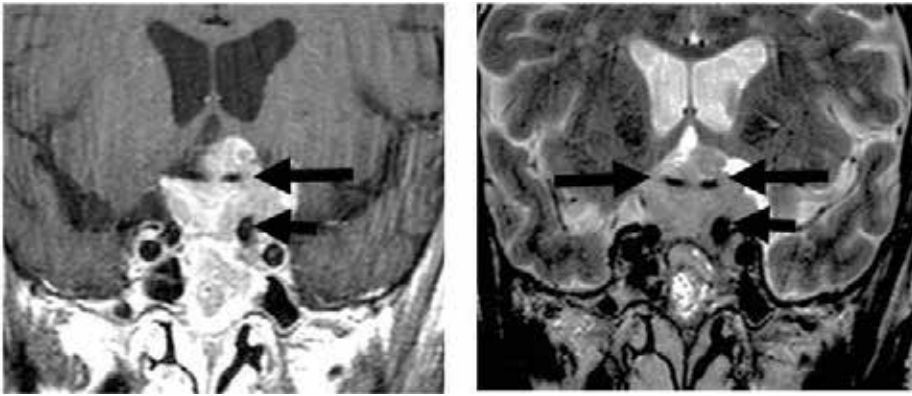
Invasive voluminous hemorrhagic noninvasive pituitary adenoma. Angio-MR image shows superior displacement of A1 tracts of anterior cerebral arteries.
